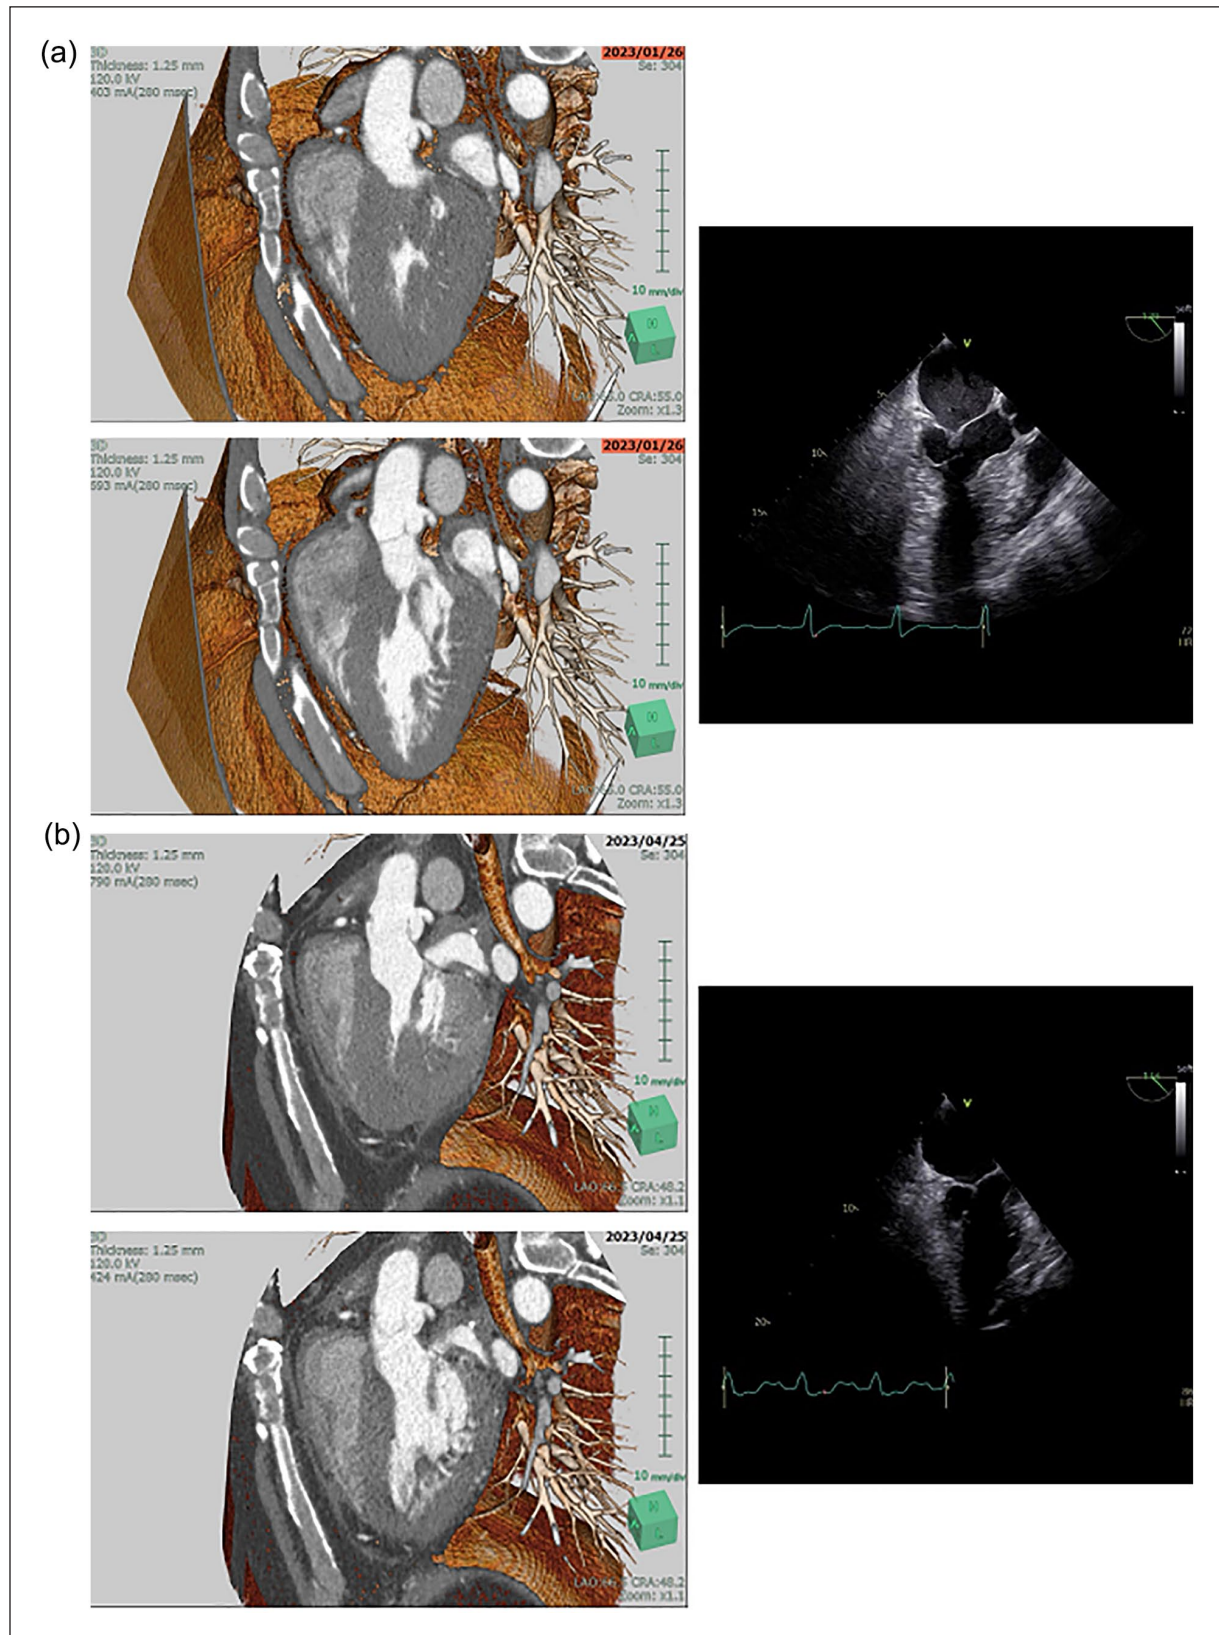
Computed tomography images. (a) Preoperative computed tomography images at the systolic (left upper) and diastolic phases (left lower). Diastolic transesophageal echography (right) showing widespread left ventricular (LV) hypertrophy from the anteroseptal wall to the apex. (b) Postoperative computed tomography images at the systolic (left upper) and diastolic phases (left lower) and transesophageal echography at the diastolic phase (right) show an improved LV cavity.
